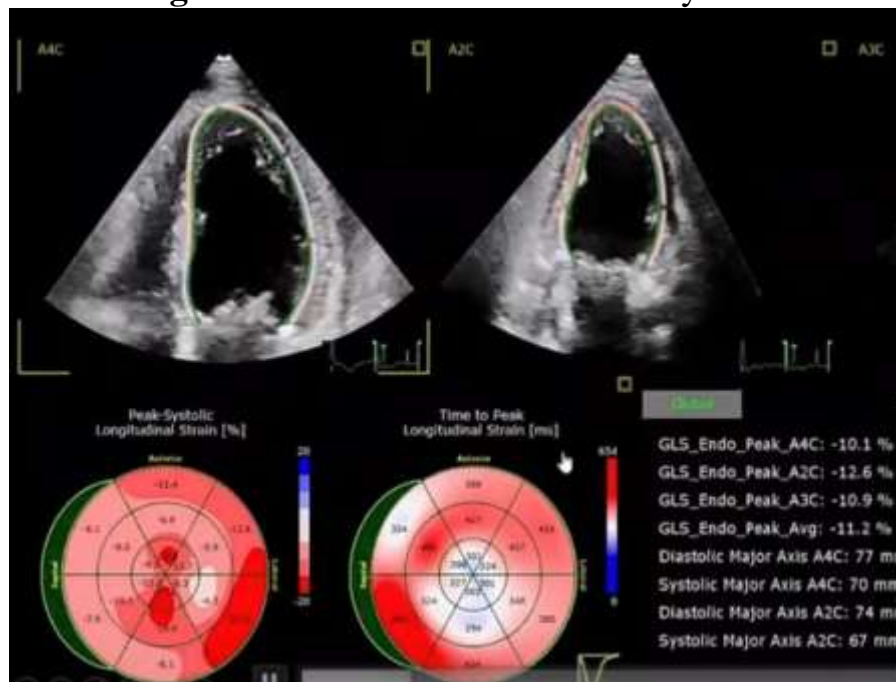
3D speckle tracking echocardiography
